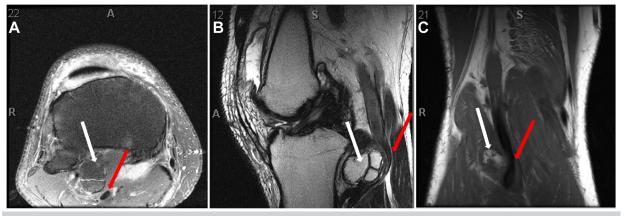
Axial proton-density fast-spin echo fat-suppressed (A), sagittal T2-weighted magnetic resonance image (B), and coronal TI-weighted fast spin echo (C) magnetic resonance images of the lower extremity, showing three large ossicles in the popliteus tendon sheath, measuring ≤ 3 cm anteroposteriorly. The ossicles (*white arrows*) resulted in deformity of the popliteal artery (*red arrows*) with a mildly narrowed lumen.
